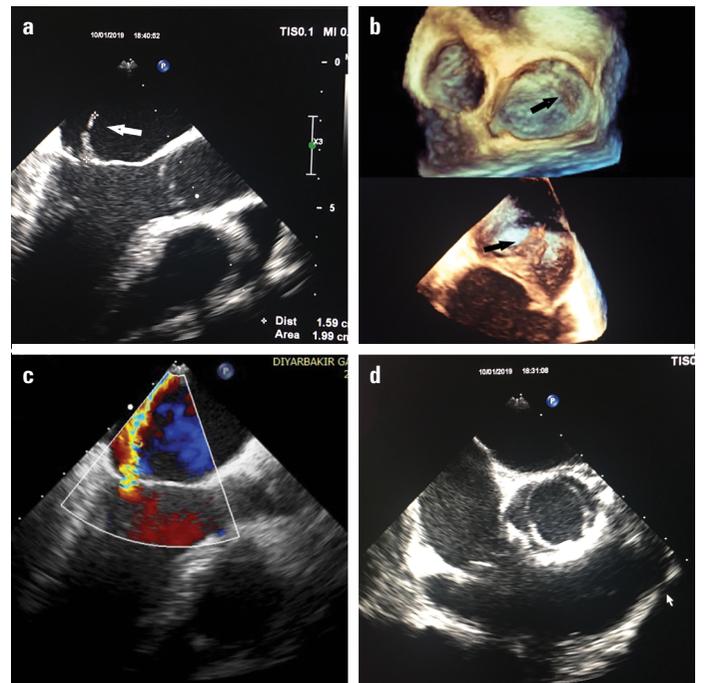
Transesophageal echocardiography. (a) 130 degree long axis view, fibrillary like vegetation seen on the anterior leaflet of the mitral valve with 15 mm diameter (white arrow). (b) Vegetation is seen on the A3 scallop of mitral valve in 3D images (black arrow). (c) 145-degree long axis view of moderate mitral valve regurgitation. (d) 45-degree short axis view of the bicuspid aortic valve
